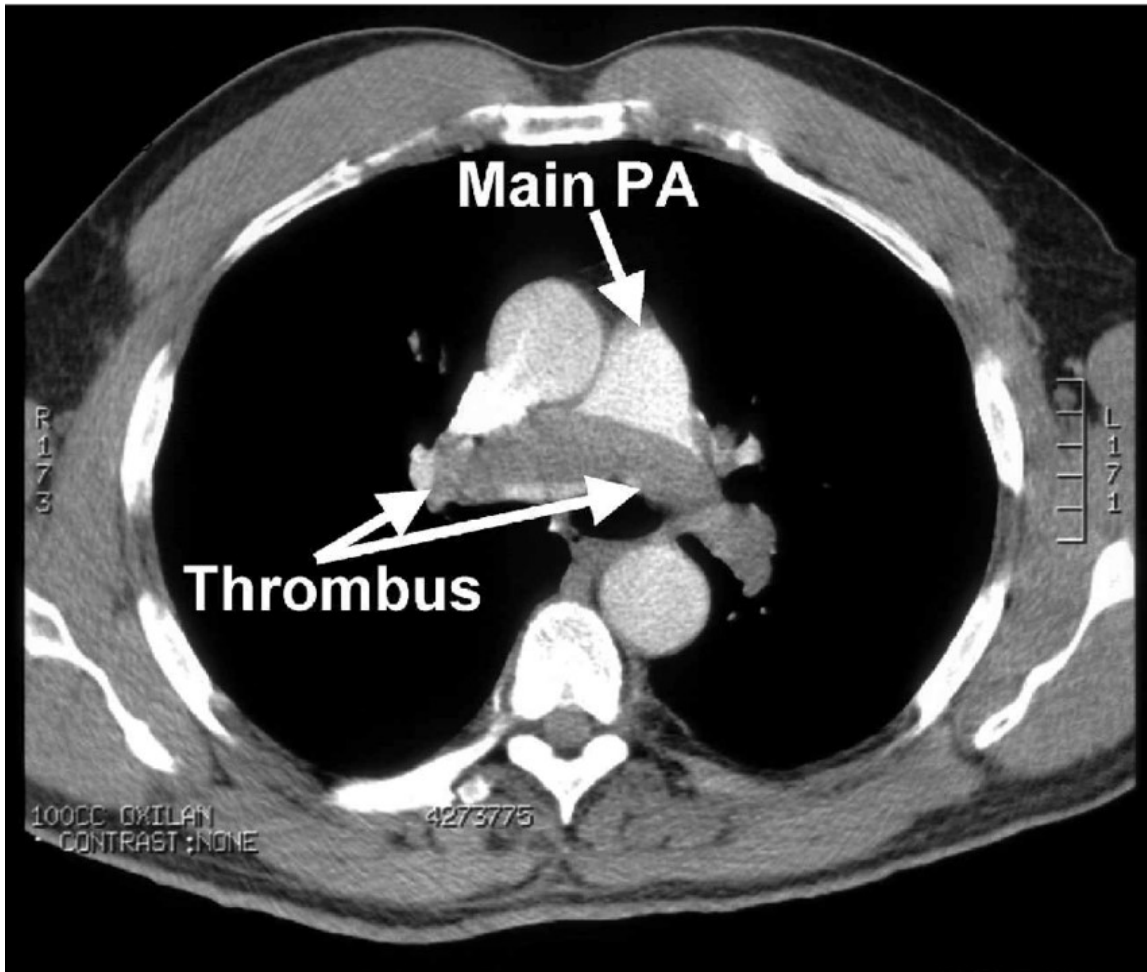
Axial CT scan image of massive pulmonary embolism. Large thrombus burden extends from body of main pulmonary artery into bifurcation and both left and right pulmonary arteries. Abbreviations: PA: Pulmonary artery. Adopted from Inonu H, Acu B. The value of the computed tomographic obstruction index in the identification of massive pulmonary thromboembolism. *Diagn Interv Radiol* 2012; 18:255 - 260.
